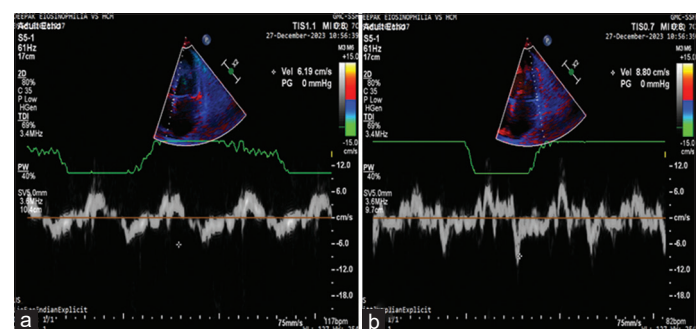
(a and b) Color Doppler flow velocity across the mitral valve
